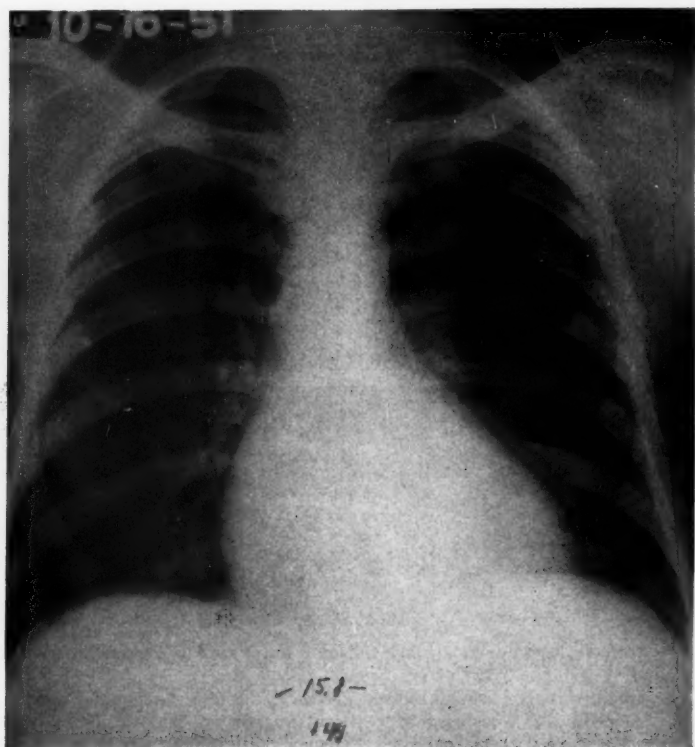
X-ray of the chest revealing straightening of the left border of the heart, with increasing size of the heart since 1950.
